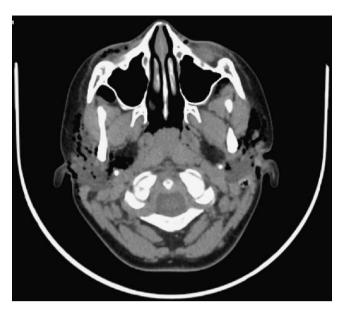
Facial CT: facial and parapharyngeal parotid emphysema.
